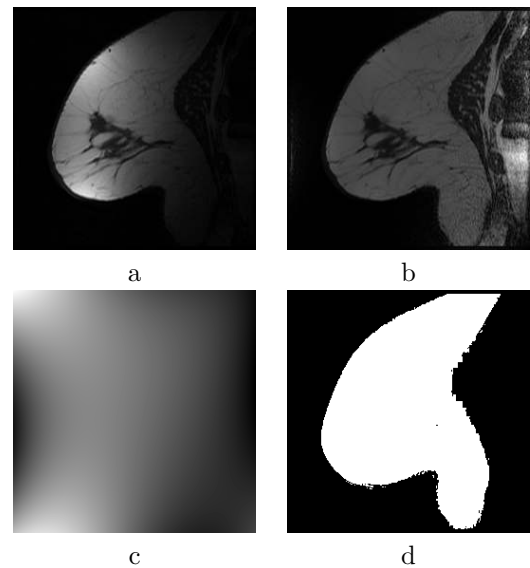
Bias field correction of a breast MRI image (classes fat tissue and mammary ducts glands and connective tissue; Legendre polynomials up to third degree). a : Original image. b: Corrected image. c: Computed bias field. d: Class-mask
